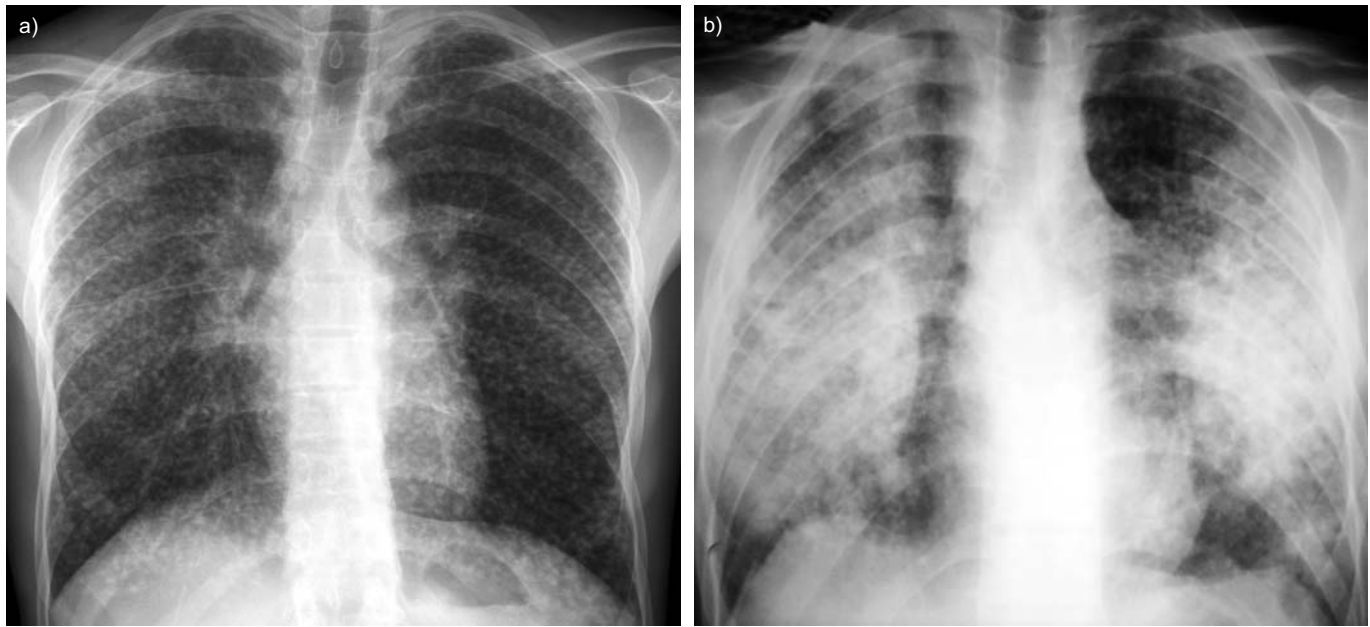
Chest radiographs belonging to two different ex-denim sandblasters showing a) bilateral small, widespread nodules and b) large type C opacities.
